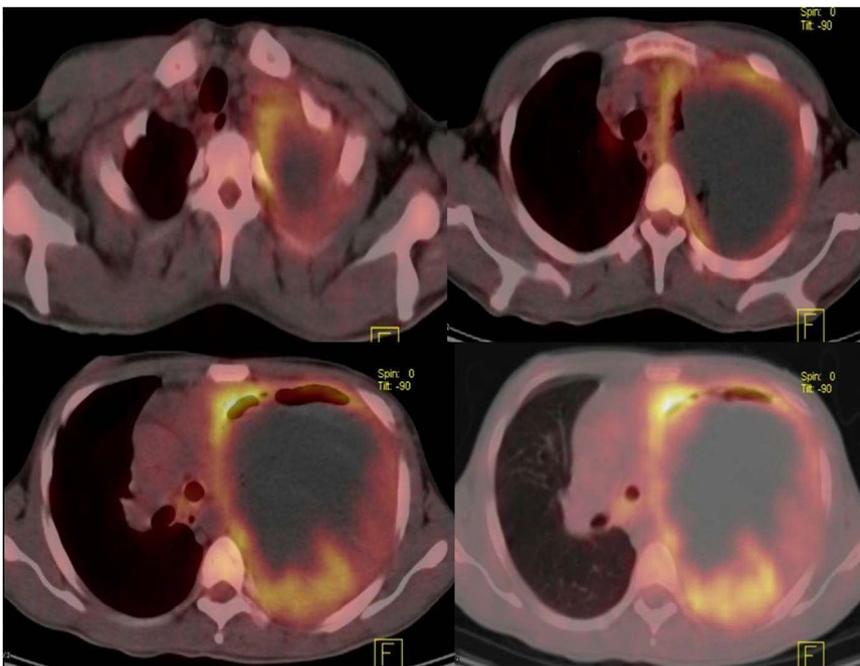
Transaxial PET/CT images in soft tissue & lung window. showing. a large pleural based soft tissue density lesion, starting from the apex of lung, filling almost the entire left hemithorax with peripheral FDG uptake with central area of hypometabolism and mediastinal shift to right.
